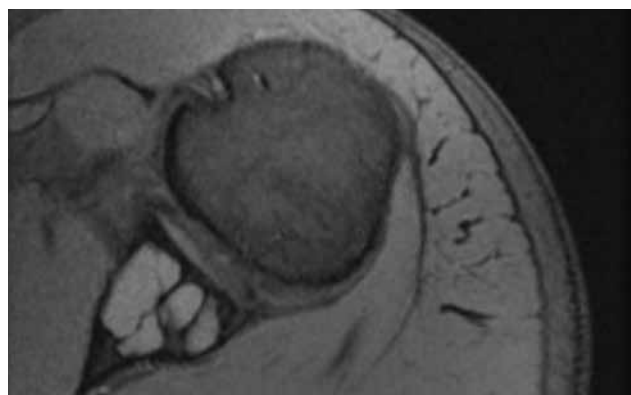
Case 2 axial magnetic resonance imaging confirms presence of large cyst involving nearly entire portion of inferior
